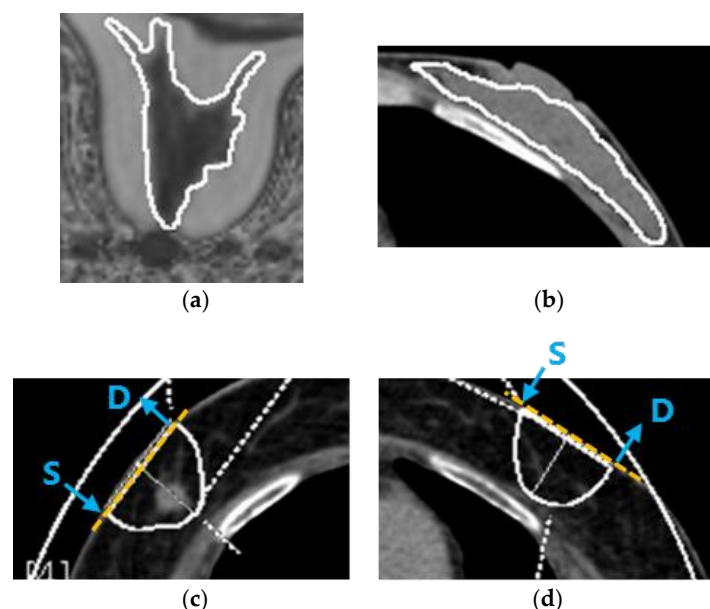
ROIs on MRI and DECT. (a) ROI on an MRI image of fibroglandular tissue in a normal breast in the first part of the study. (b) ROI on a DECT image of fibroglandular tissue in a normal breast in the first part of the study. (c) ROI on a DECT image of breast cancer in the second part of the study. (d) ROI on a DECT image in a symmetrical area of the contralateral breast in the second part of the study. Yellow dashed lines show the measurement axes for TD-DOS. Blue arrows indicate the position of the source (S) and detector (D) fiber bundles.
